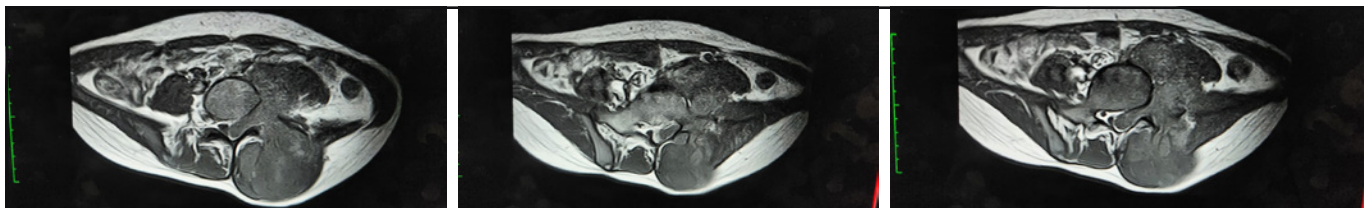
MRI T1 images axial cuts showing a low signal mass with extensions as described above.
